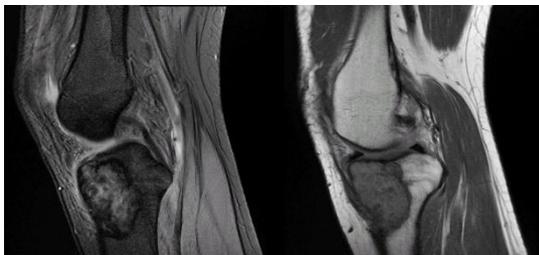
Nuclear Magnetic Resonance Images sagittal slices.
